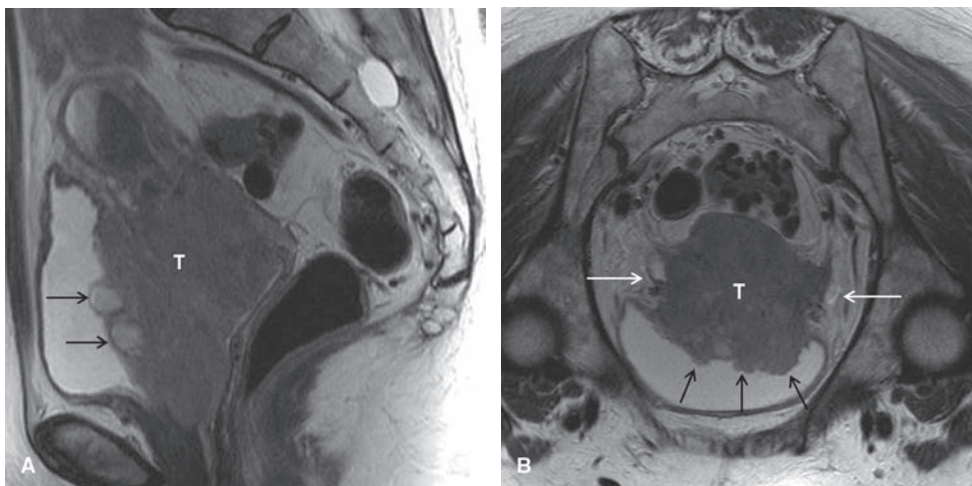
Stage IVA cervical carcinoma. Sagittal (A) and axial oblique (B) T2V FSE MR images show a large cervical cancer (T in A, B) that invades the cervical stroma and extends into both parametria as indicated by a spiculated tumor to parametrium interface. Tumor also invades the bladder mucosa (black arrows in A, B) and both distal ureters (white arrows in B) causing bilateral hydronephrosis.
